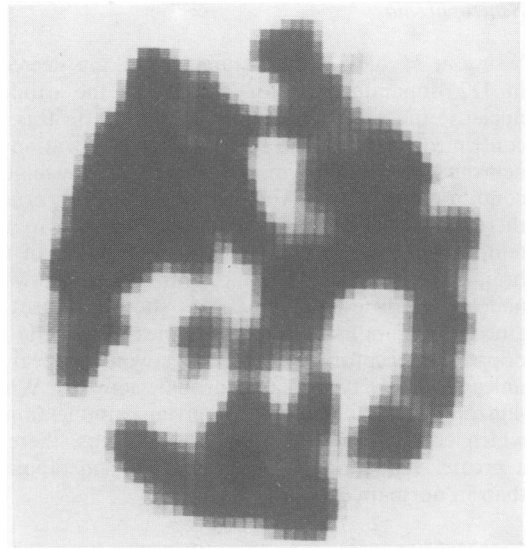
SPECT image using technetium-99m HM-PAO of a cerebral section from an elderly woman with multi-infarct dementia.
